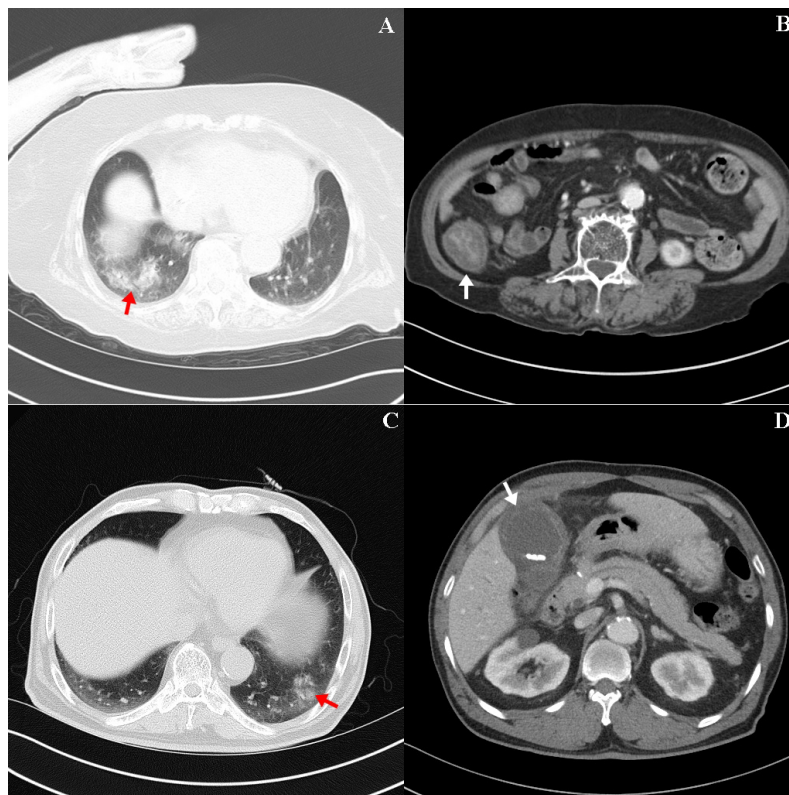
Examples of co-infection sources on combined chest and abdominal CT in this study. (A,B) show co-infection sources of pneumonia (red arrow—patchy consolidation in right lower lobe) and colitis (white arrow—edematous wall thickening of ascending colon) in an 87-year-old woman. (C,D) show pneumonia (red arrow—focal, peri-bronchial ill-defined consolidation) and acute cholecystitis (white arrow—thick enhance gall bladder wall and multiple stones) in a 72-year-old man.
